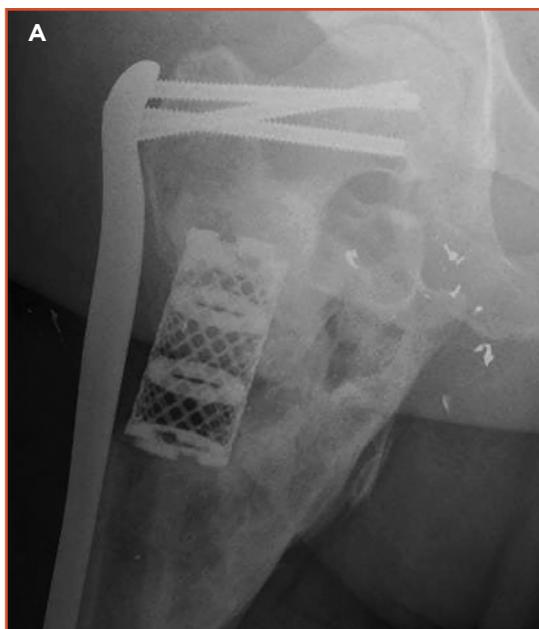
At 15 months after revision open reduction and internal fixation, radiographs of the right hip show the titanium mesh cage and proximal femur locking plate. A) Anteroposterior view. B) Lateral view.
